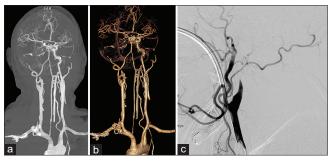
(a) Coronal computed tomography angiography image demonstrating occlusion of the right internal carotid artery just distal to the bifurcation of the right common carotid artery. (b) Coronal three-dimensional reconstruction of the computed tomography angiography image in Figure 2a. (c) Lateral digital subtraction angiography with injection into right common carotid artery demonstrating occlusion of the right internal carotid artery near the bifurcation of the right carotid bifurcation
